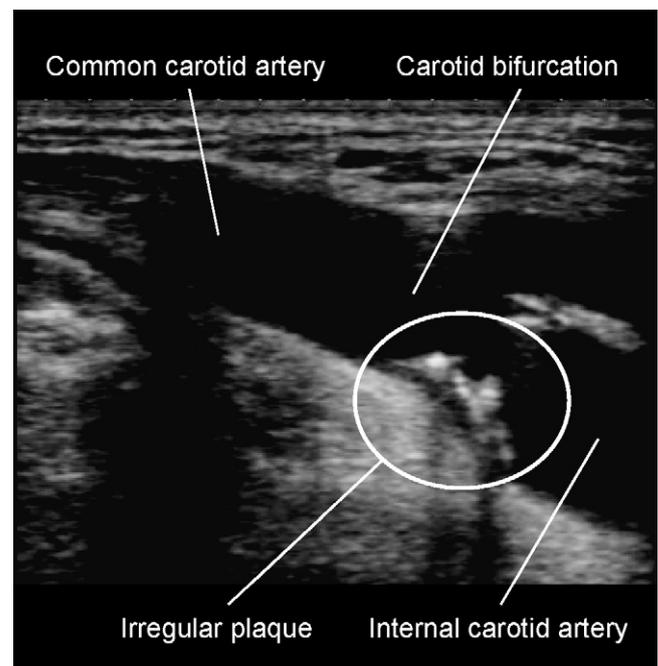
Carotid ultrasound image of carotid complex plaque.
